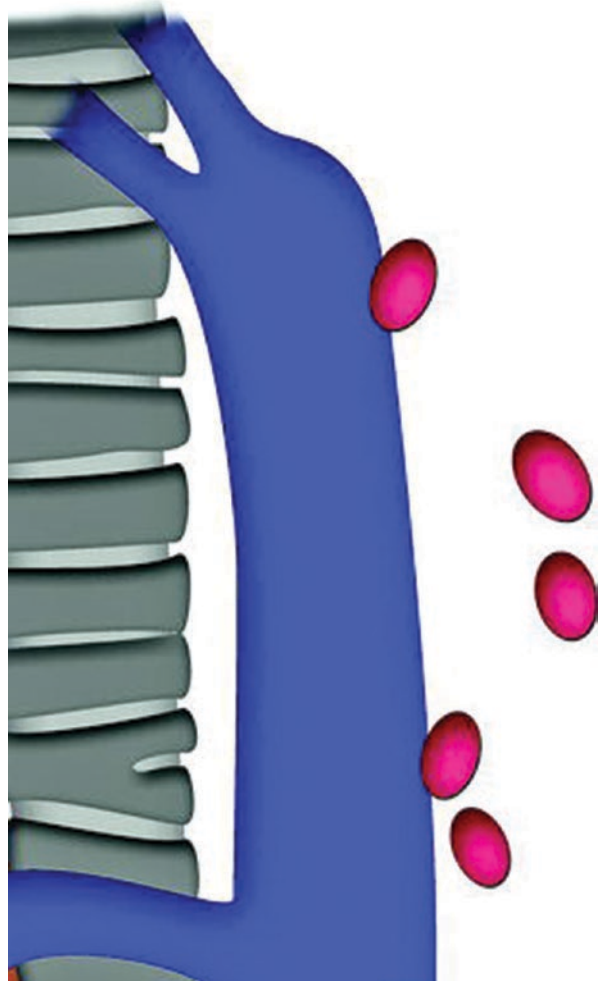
(a, b) Contrast-enhanced axial CT scan shows an enlarged lymph node in the prevascular space on the left side, anterior to the arch of aorta (*red*)
